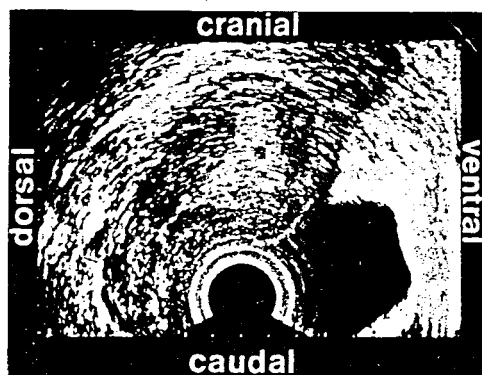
Transvaginal sonography : correct image of the longitudinal section of an anteverted uterus using a frontally radiating sector scanner.
